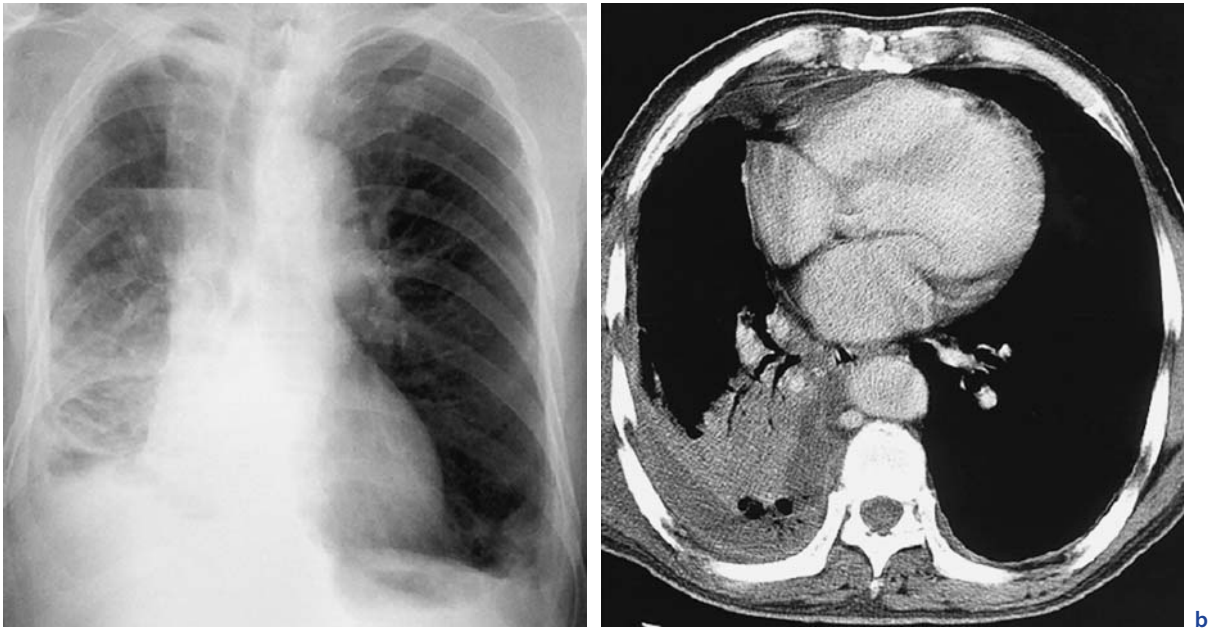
a Chest radiograph and b in a double-lung transplant recipient. Both modalities show postoperative atelectasis
